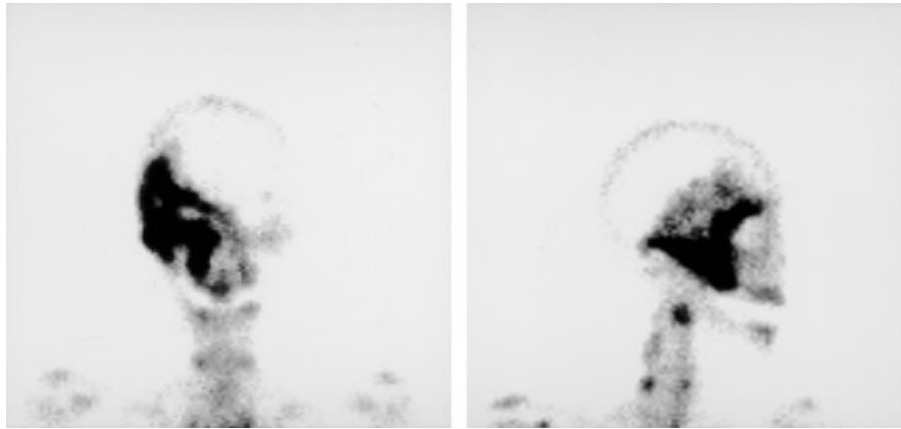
Bone scintigraphy with Tc-99 m showing marked uptake in the area from the right temporal bone to the maxilla.
